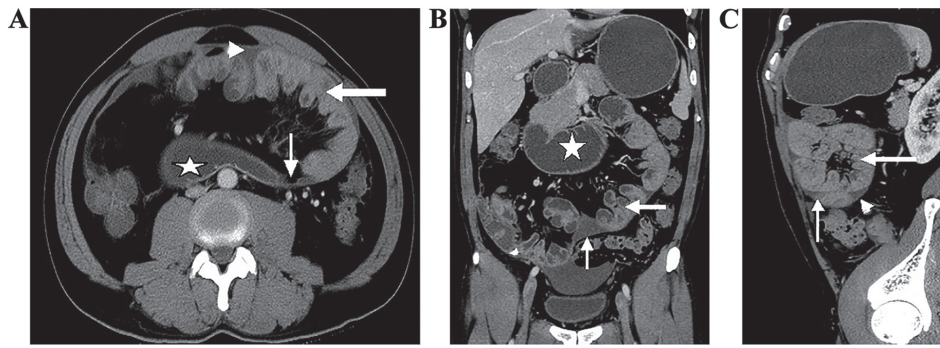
CT findings of abdominal cocoon disease. CT of the (A) abdomen axial, (B) coronal reformatted and (C) sagittal reformatted show the small bowel contained within a sac. The thickened enhancing membrane (short and thin arrows) covering congregated small bowel loops (thick white arrows) are visible and ascites (white triangle) around loops and the dilated loop of duodenum with fluid (stars) are also visible due to intestinal obstruction. The second and third part of the duodenum mimic the Bottle Gourd appearance (stars).
